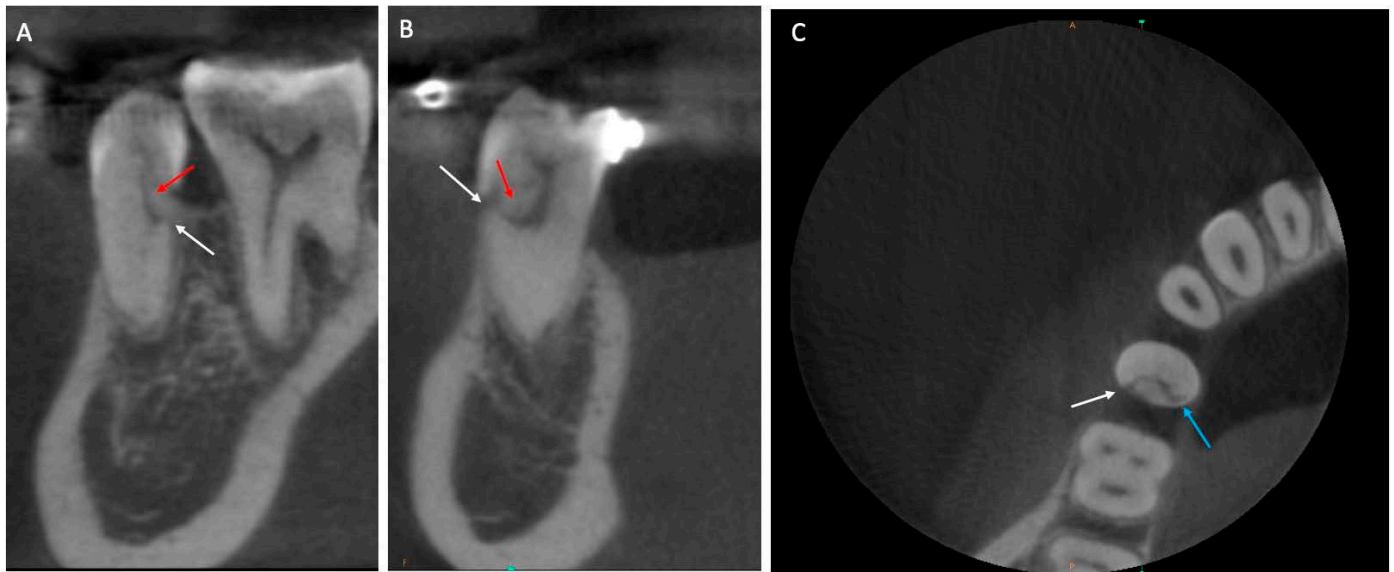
Reconstructed CBCT images of the #45 tooth, showing signs of the external cervical resorption (ECR): portal of entry (white arrows), bone-like tissue apposition (red arrows), the extent of the resorption (blue arrow). (A)—coronal; (B)—sagittal; (C)—axial slices.
